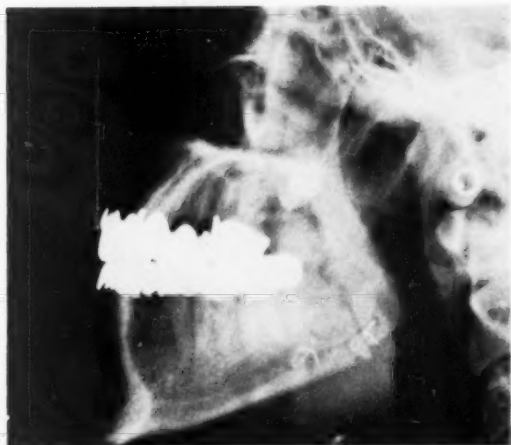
Post-operative X-ray of an angle osteotomy.
